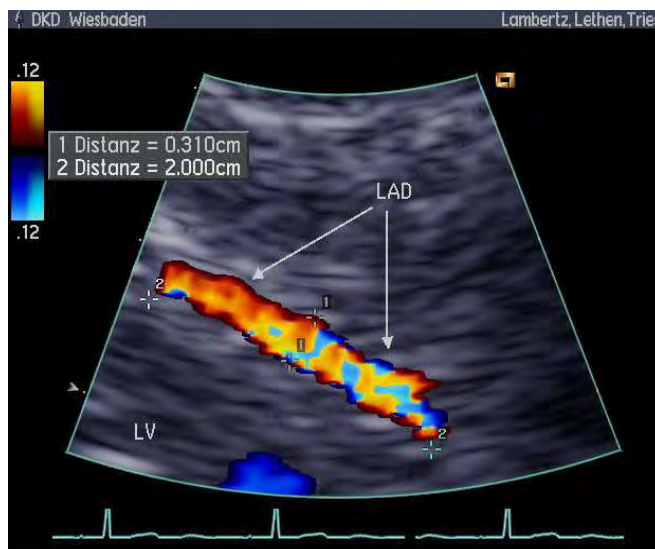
Modified PLAX view allowing color Doppler assessment of coronary blood flow in the mid segment of the LAD (Heinz Lambertz et al., 2004).
